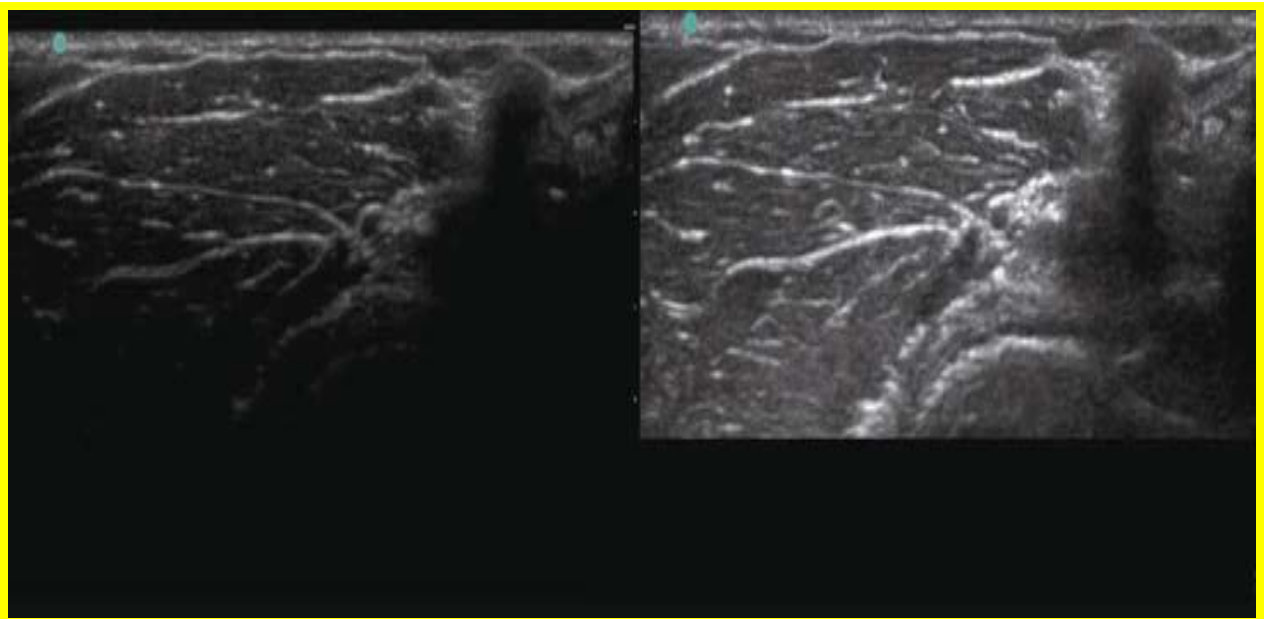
Needle misalignment is common and can lead to incorrect identification of the needle tip. In the two ultrasound images the needle has not moved, but because of misalignment the needle tip position appears different.
